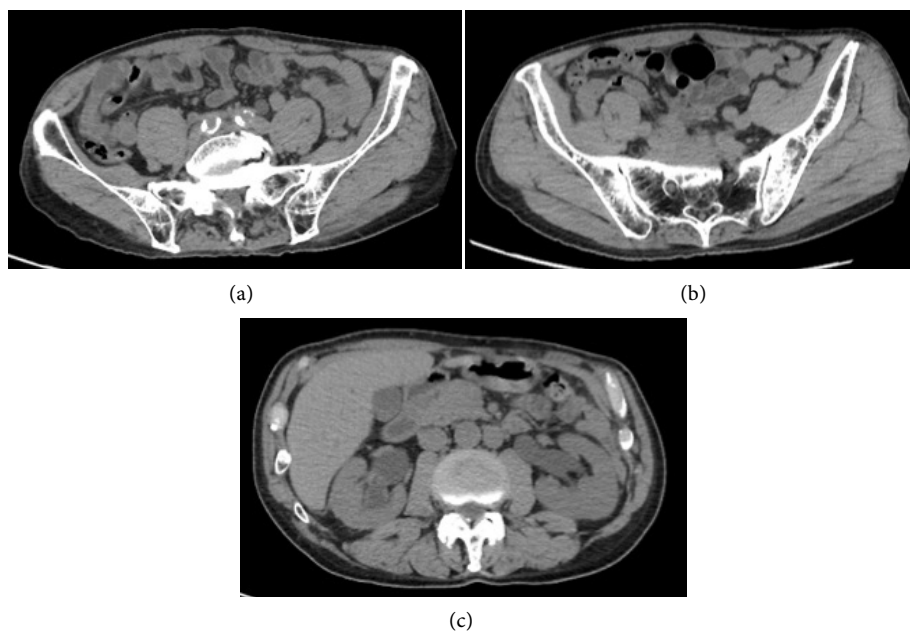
Computed tomography showed a soft-tissue density mass with an irregular border in the retroperitoneum (a)-(b). The mass involved bilateral ureters and had caused bilateral hydronephrosis (c).
